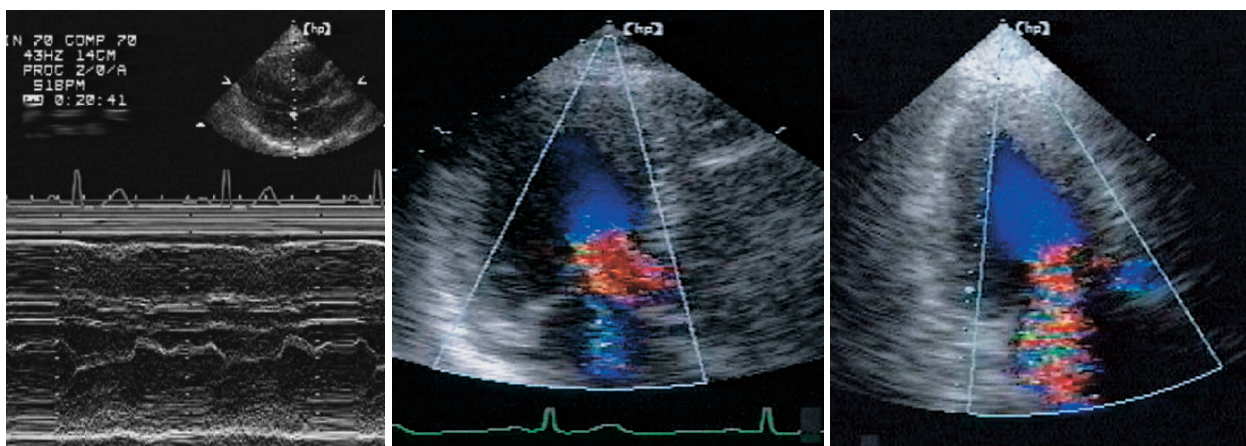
M-mode echocardiograms
